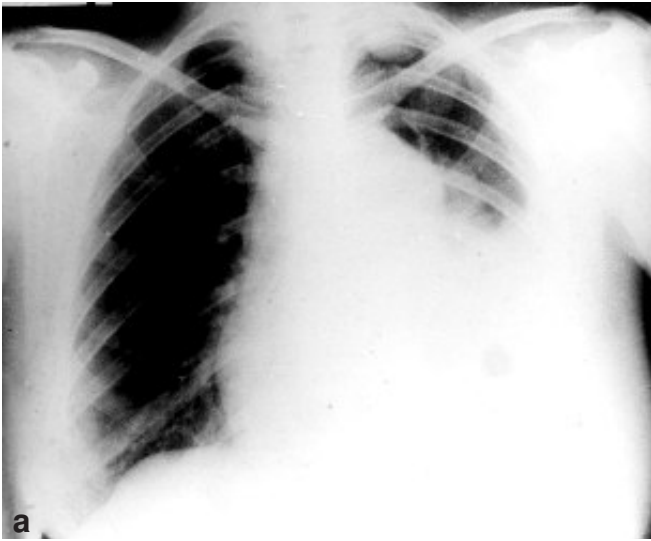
Patient 1. a), chest roentgenogram. b) linear tomography. Note multiple pleural masses.
